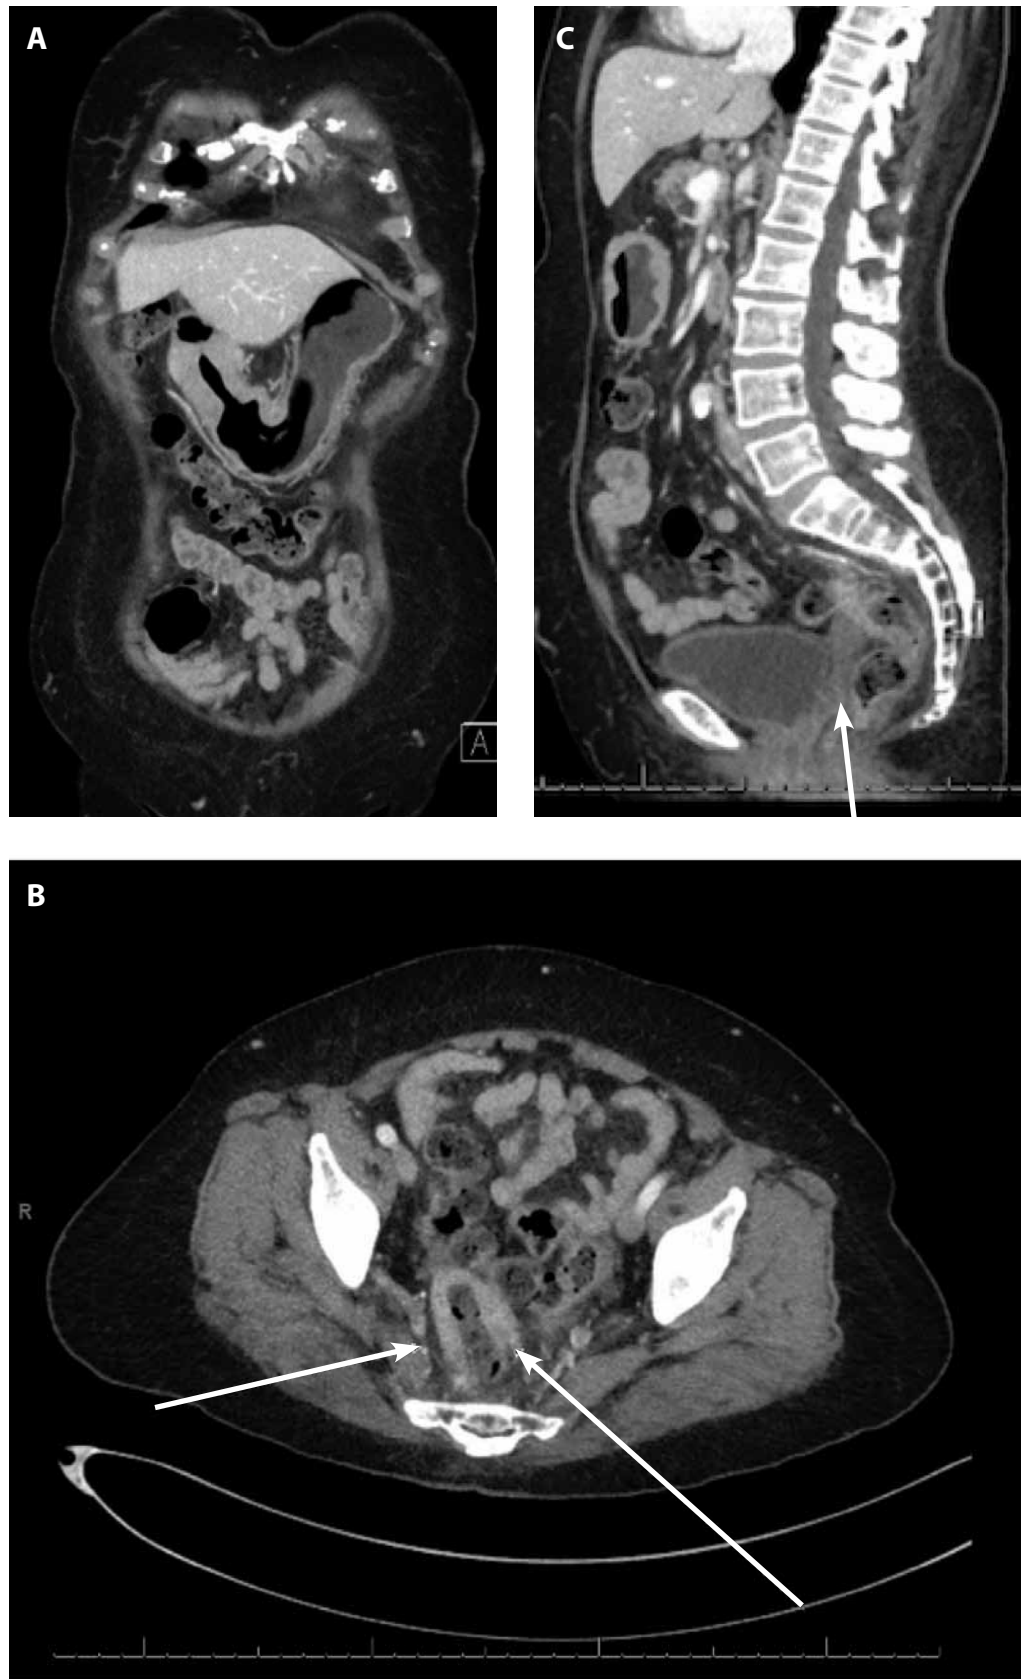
CT findings. A: Coronal view shows diffuse thickening of the gastric antrum. B: Transverse view shows thickening of the rectosigmoid (arrows). C: Sagittal view shows fat stranding (arrow) associated with colonic involvement.
